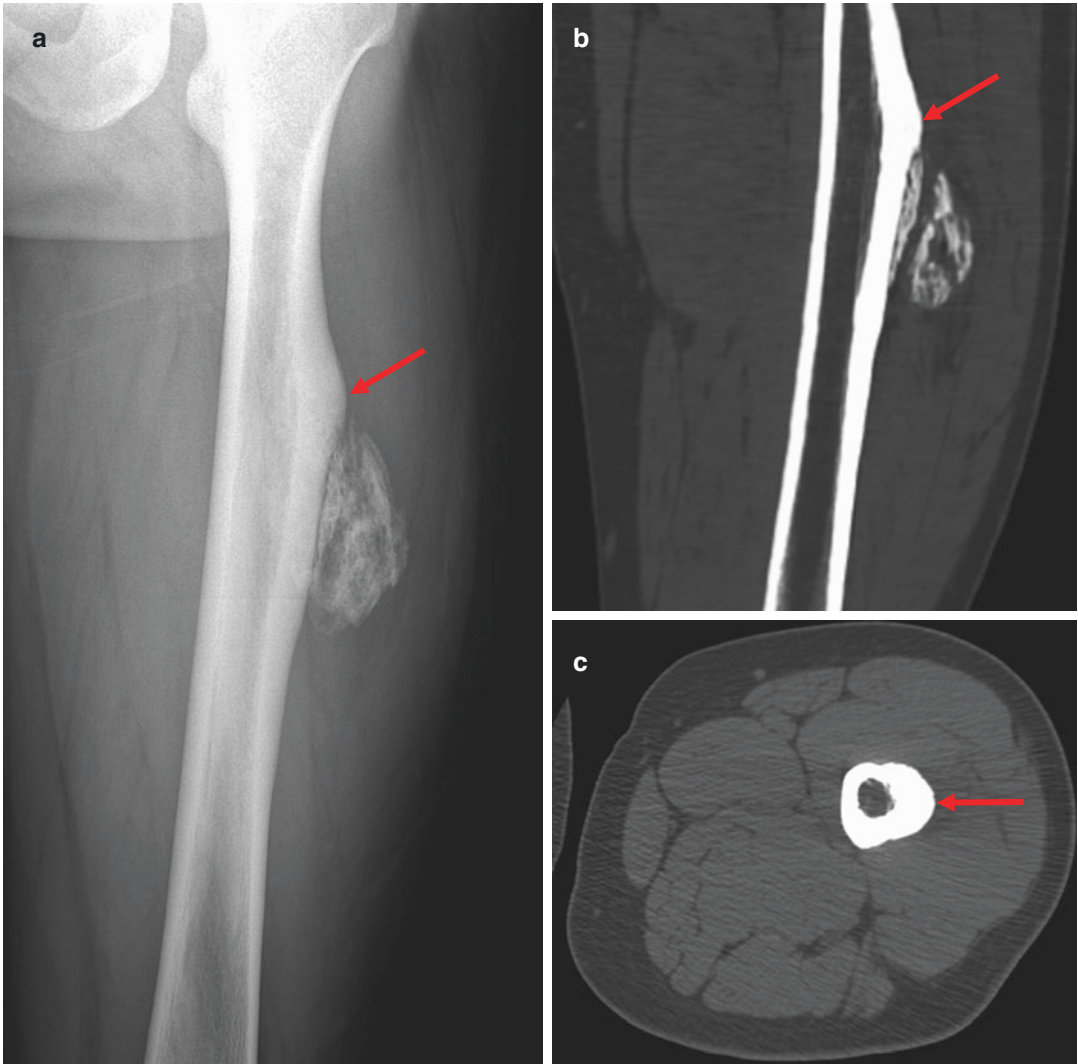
Ossifying hemangioma. AP radiograph (a) shows cortical hyperostosis (*arrow*) of the left femur and a juxtacortical ossified mass. Coronal and axial CT
